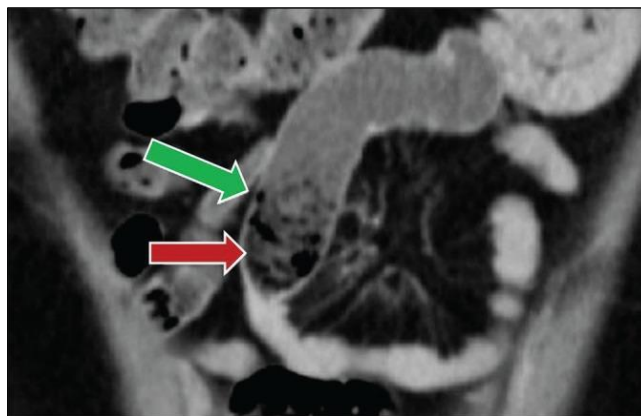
Coronal CECT showing the 'beak sign' (green arrow) and 'small bowel feces sign' (red arrow) in small bowel obstruction due to adhesion key CT signs described in this study
